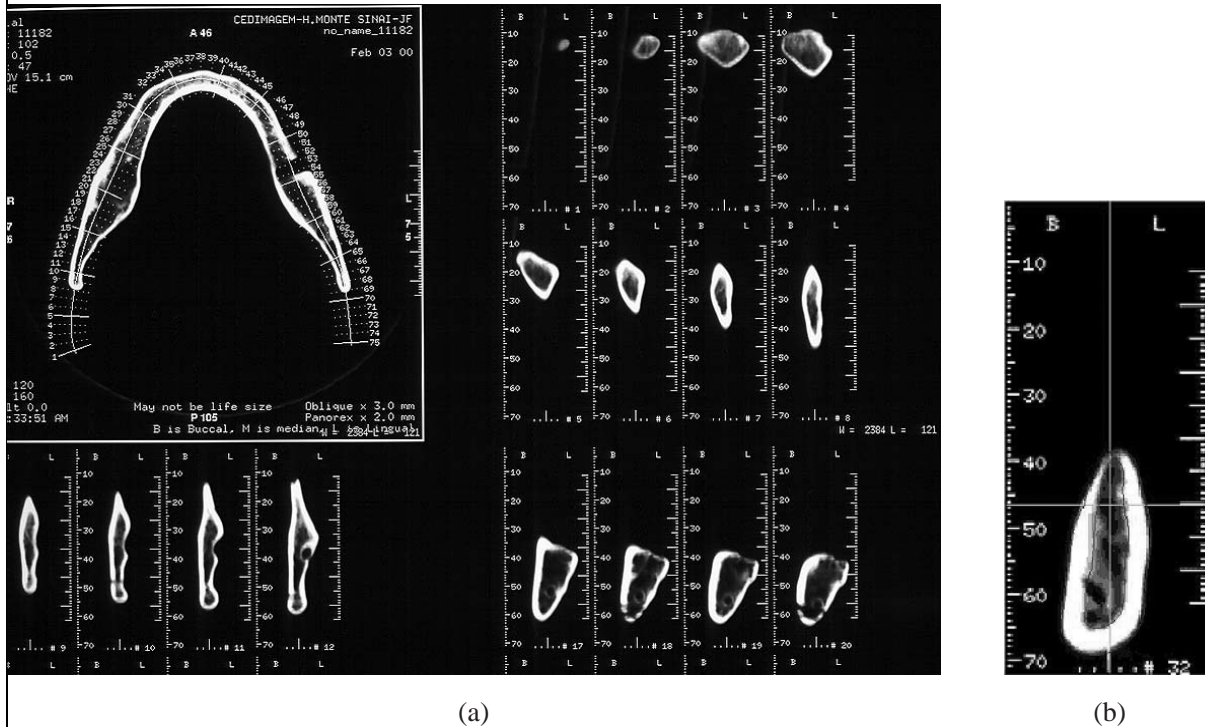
(a) Mandible CT scan. (b) Transverse section # 32, implant location.
